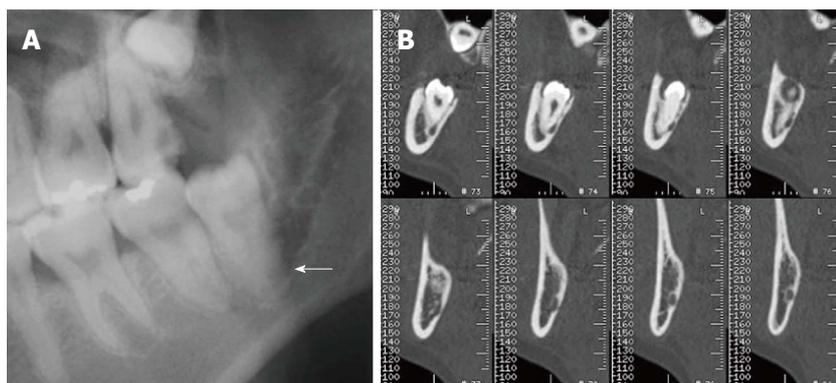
Root darkening and altered third mandibular molar (LM3) root. A: Darkening of the root observed by orthopantomography. A black band is visible (white arrow) at the root apex site; B: Alteration of the LM3 root (grooved) and loss of the lingual cortex of mandibular bone can be observed on cross-sectional multi-detector computed tomography images.
